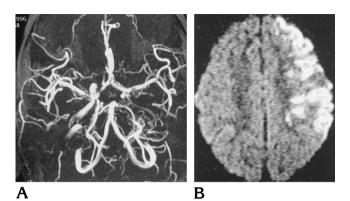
MR imaging in hyperacute infarction.
